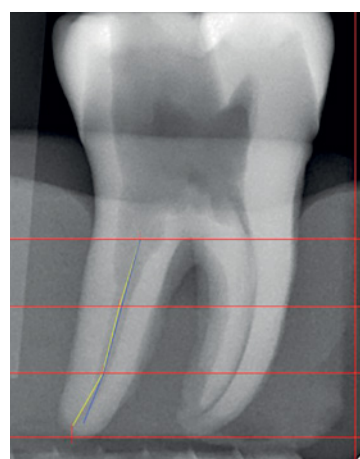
X-ray showing superposition of the curves before and after instrumentation
